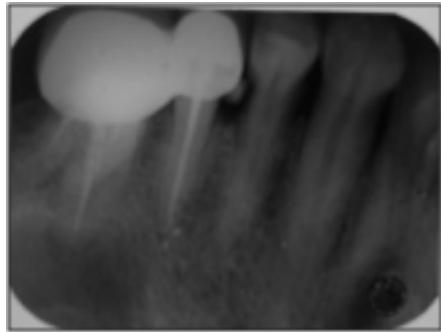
Radiograph with detach fragment (pre-operative)
